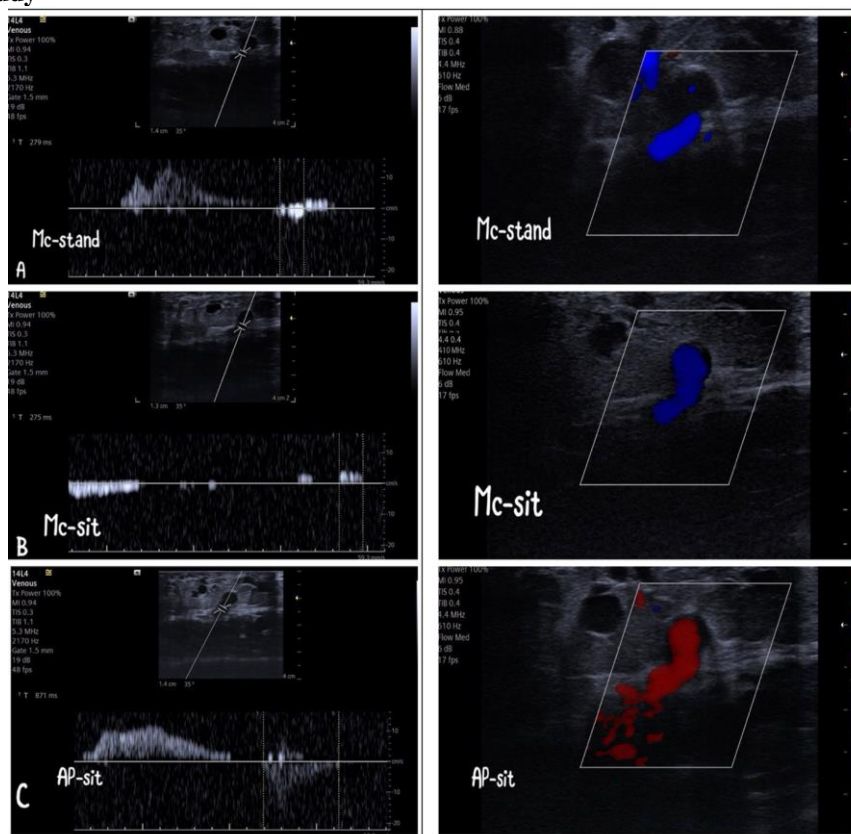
Color and spectral Doppler ultrasound of a calf perforator vein demonstrating the venous flow using three different methods. In the standing position with manual muscle compression (MC-stand), forward flow toward the deep venous system is observed with reflux duration of 279 ms. In the sitting position with manual compression (MC-sit), forward flow is also noted with reflux duration of 275ms. During the ankle pump maneuver in the sitting position (AP-sit), reverse flow (reflux) from the deep to the superficial system becomes evident with reflux duration of 871ms, indicating perforator vein incompetence.
